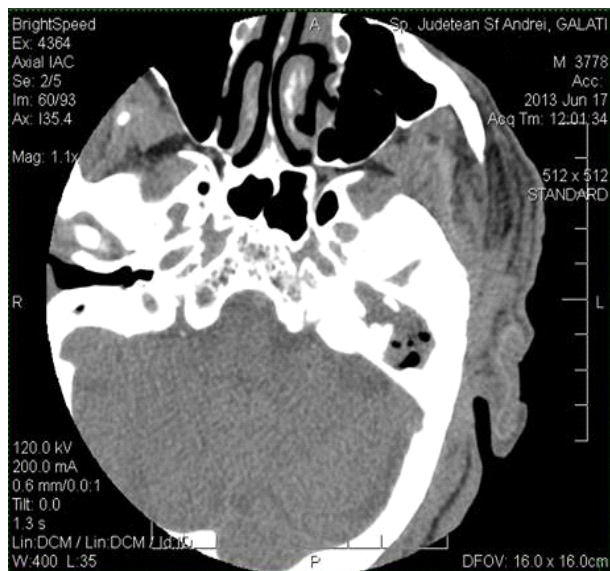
Cranial-mastoid CT - left otomastoid abscess extended epicranially without intracerebral damage. (22/07/2013)
